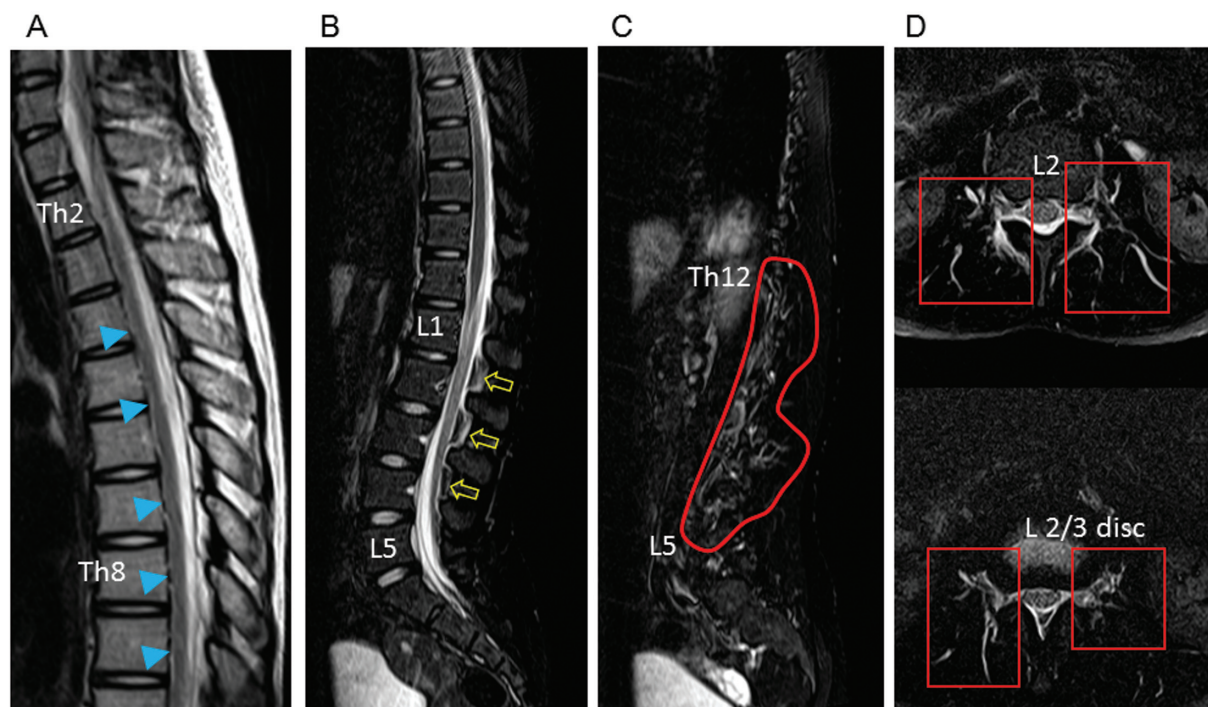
Spinal MRI 3 days after lumbar puncture in case 2, who presented with orthostatic headache. Midsagittal T2-weighted image (T2WI) at the thoracic level (A) shows an extreme anterior shift of the spinal cord (*arrowheads*). Midsagittal T2-fat saturated (T2-FS) image at the lumbar level (B) shows the DTS (*arrows*). The right paramedian sagittal T2-FS image at the lumbar level (C) shows CSF exudation around the dural sleeves (*encircled by red line*). Axial T2-FS images at the lumbar level show CSF exudation into the paravertebral space (*red squares*).
